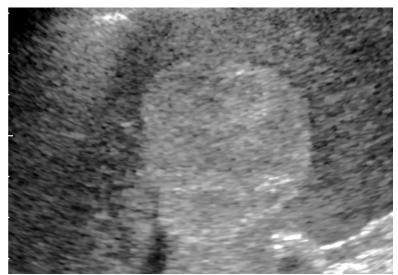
Seems to be large haemangioma (with clinical wellness and normal "liver values" wait-and-see monitoring procedure with sonographic check-ups possible, no CT or MR examination); SCS
